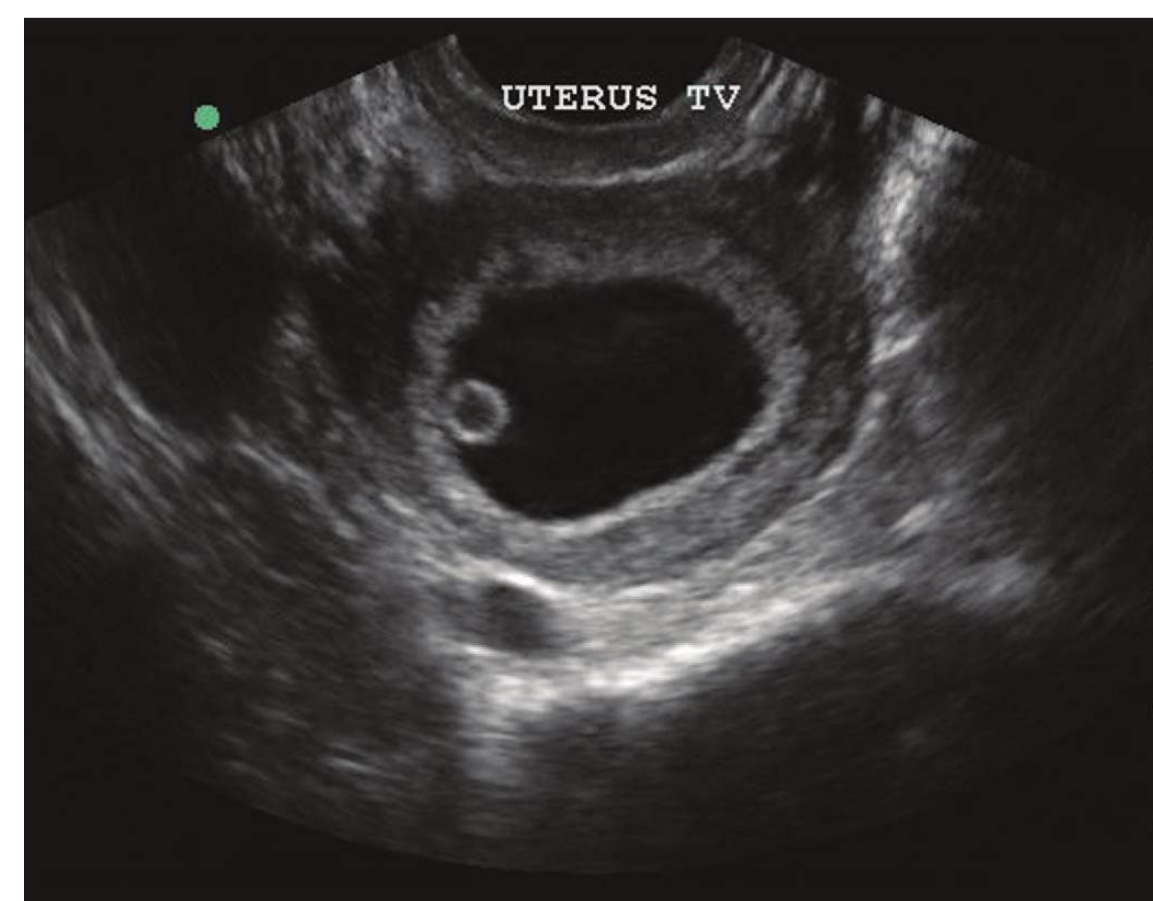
■ Intrauterine Yolk Sac. Discrete ring of an intrauterine yolk sac within the gestational sac seen on transvaginal ultrasound. Definitive diagnosis of IUP can be made once a yolk sac is seen. A double decidual sac sign is also seen. (Photo contributor: Lauren Oliveira, DO.)
